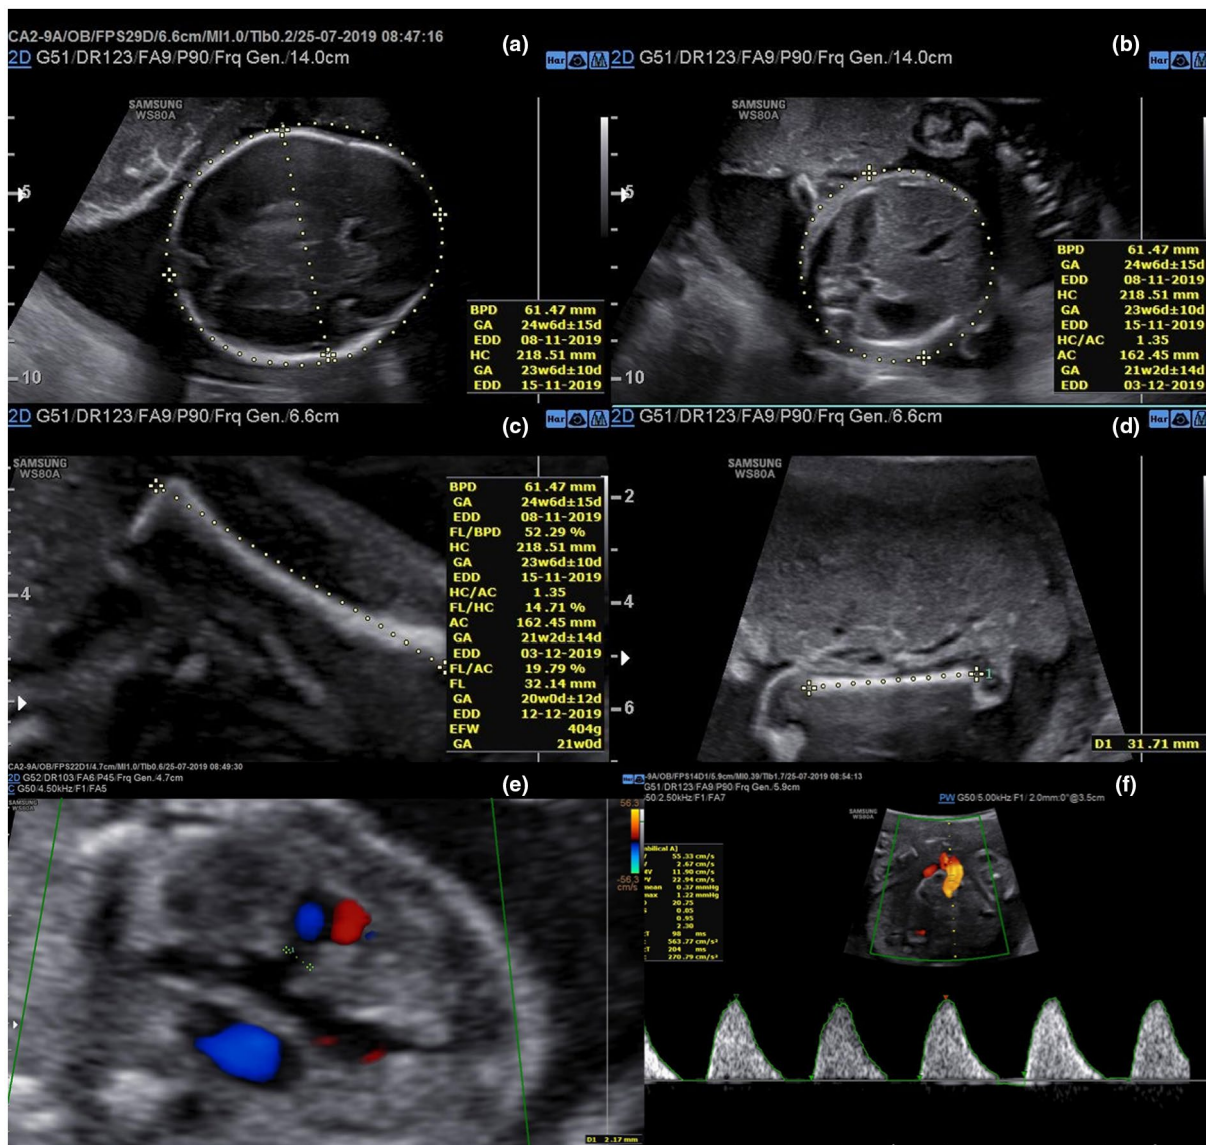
Ultrasound features of the fetus at 27 weeks of GA. (a) BPD of 61.47 mm and HC of 218.51 mm; (b) AC of 162.45 mm; (c) FL of 32.14 mm; (d) HL of 31.71 mm; (e) ventricular septal defect, 2.17 mm in size; (f) absent umbilical artery diastolic flow
